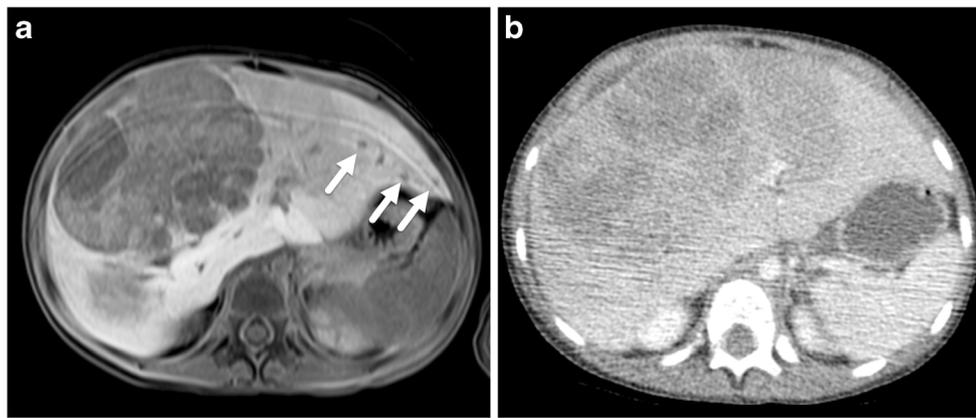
Multifocal disease on MRI and CT. a Axial T1-weighted MRI obtained in the hepatocyte phase after administration of a hepatocyte-specific contrast agent in a child with hepatoblastoma shows a dominant mass in the right lobe of the liver. Note the multifocal disease
